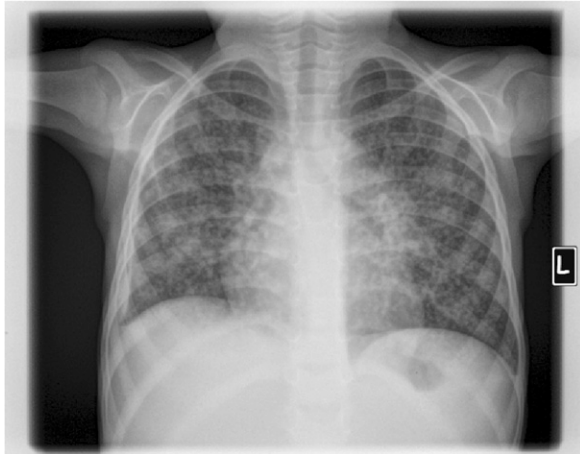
Chest radiograph revealing innumerable diffuse micronodules throughout both lungs along with bilateral perihilar adenopathy, left greater than right.
